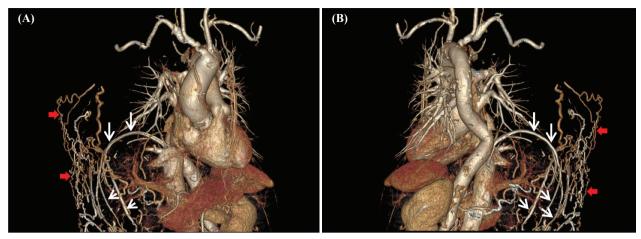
Anterior view (A) and posterior view (B) of 3-dimensional reconstruction of the chest CT image showed right phrenic collateral (white arrows) and chest wall collateral (red arrows).
